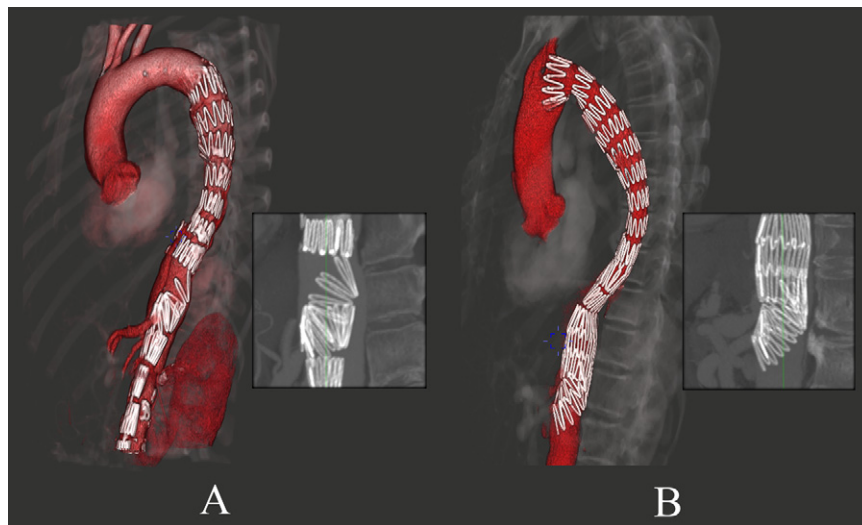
Postoperative computed tomography (CT) scan after deployment of the Zenith Dissection Endovascular System (ZDES) showing misalignment of the bare stent. A, Misalignment of the proximal bare stent (one case). B, Misalignment of the distal bare stent (four cases).
